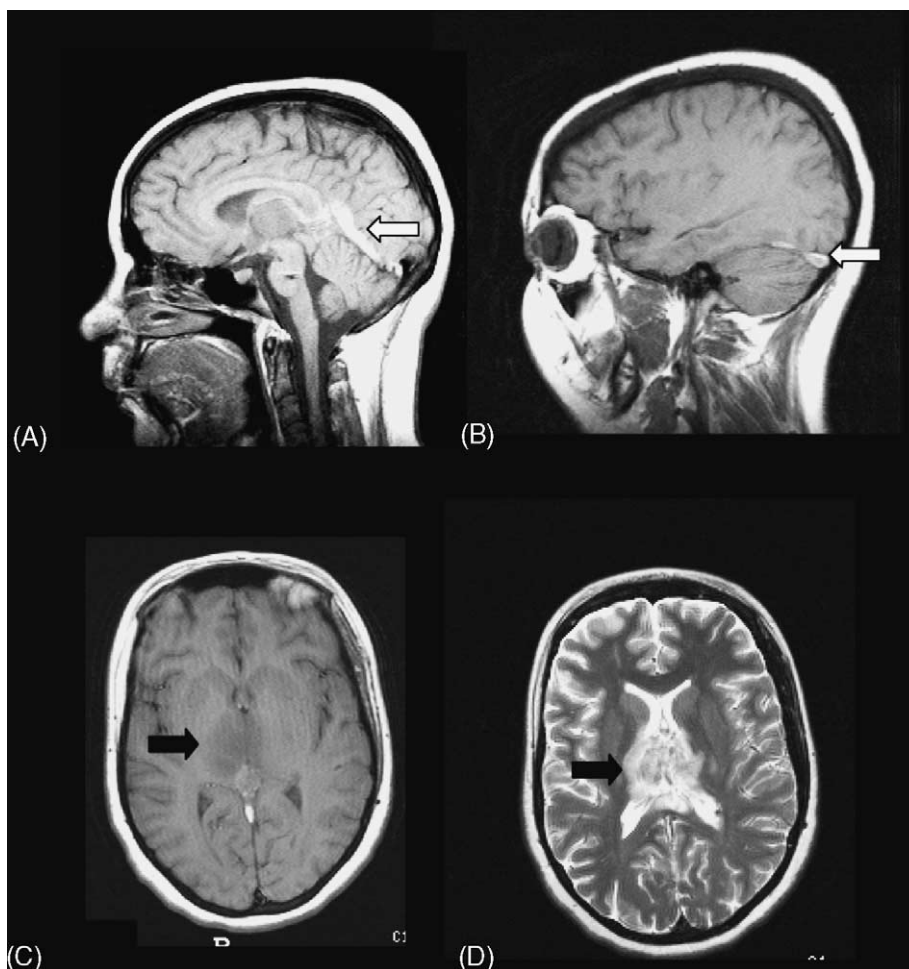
MRI of patient (#19) with systemic lupus erythematosus and antiphospholipid antibodies showing (A, B) sagittal T1 images without gadolinium showing a thrombus (arrow) in the straight (A) and transverse (arrow) (B) sinuses (hyperintense signal); (C) axial T1 image with hypointense signal in thalami (arrow) and (D) axial T2 image with heterogeneous signal intensity, corresponding to bilateral venous infarct and edema in thalami (arrow).
